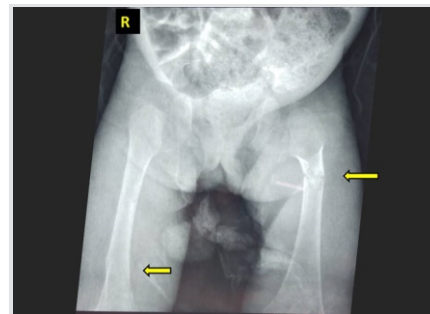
Anteroposterior radiograph of bilateral hips and femur. Right - distal femur fracture (AO 32-A1), Left - proximal femur fracture (AO 32-A3) - Add AO classification!.
